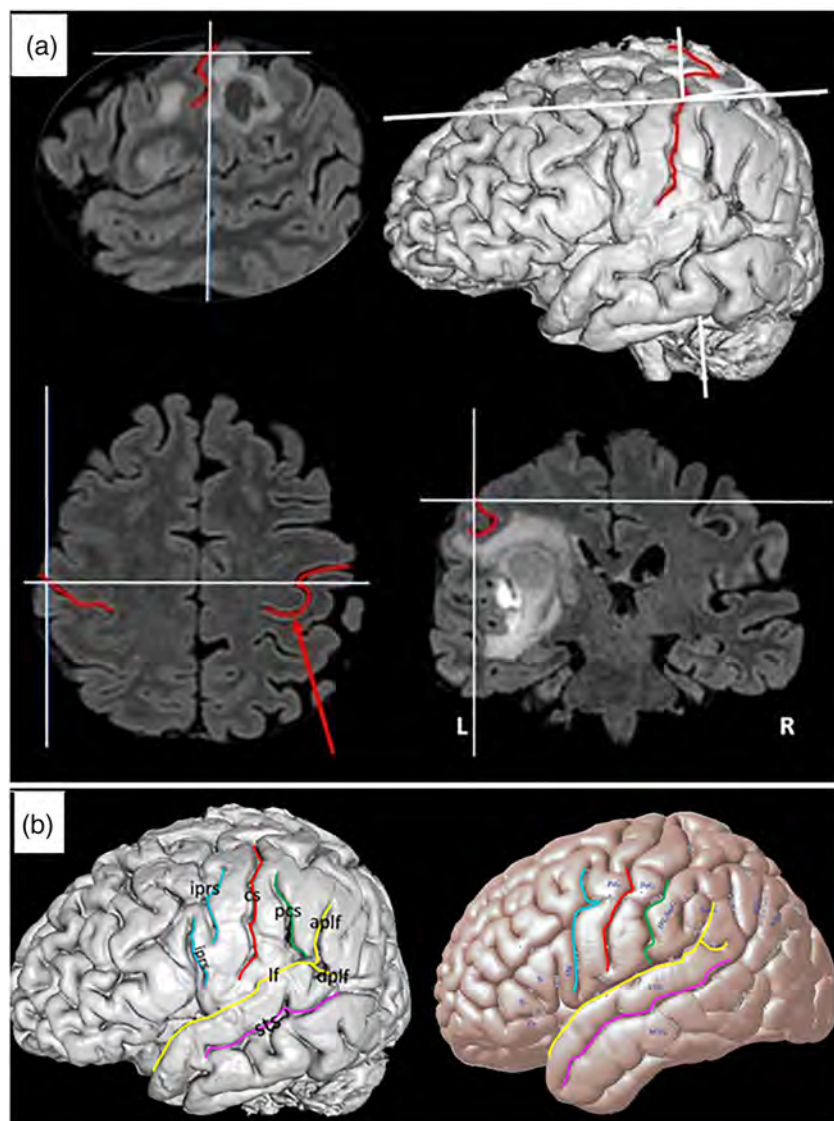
(a) Surface reconstruction of the MRI of the left hemisphere of the patient (top right side) with axial, coronal and sagittal planes (left side) to show the location of the brain tumour below the cortical surface. The white cross-points indicate the same cursor positions on the sections and on the cortical surface reconstruction of the left hemisphere of the brain. The red lines indicate the central sulcus. The central sulcus is identified on the surface reconstruction by the hand knob detected on the axial plane within the central sulcus (red arrow) in the right hemisphere and a red outline in the left hemisphere of the brain. The brain tumour, which lies below the cortical surface, can be seen in the coronal and sagittal sections. The critical region is represented by the unaffected white matter that extends posterior to the central sulcus. L, left hemisphere; R, right hemisphere. (b) In addition to the central sulcus (see Figure 1b), other relevant sulci are identified on the brain of the patient (left panel) based on the sulci on the average MNI brain (right panel; Petrides, 2019, with Elsevier permission). *aplf*, ascending posterior ramus of the lateral fissure; *cs*, central sulcus; *dplf*, descending posterior ramus of the lateral fissure; *iprs*, inferior precentral sulcus; *lf*, lateral fissure; *pcs*, post-central sulcus; *sts*, superior temporal sulcus
